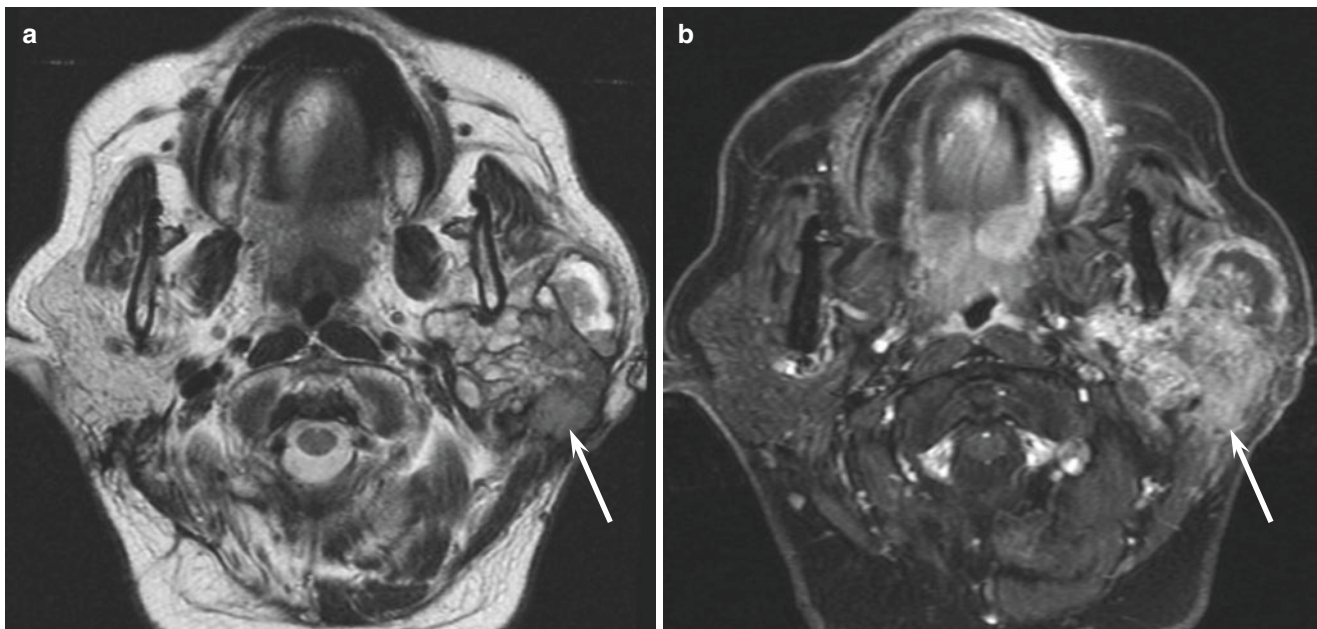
A 61-year-old woman with adenocarcinoma NOS of the left parotid gland. (a) T2-weighted image shows a considerably heterogeneous lesion (arrow) with a mixture of solid and cystic components. (b)
